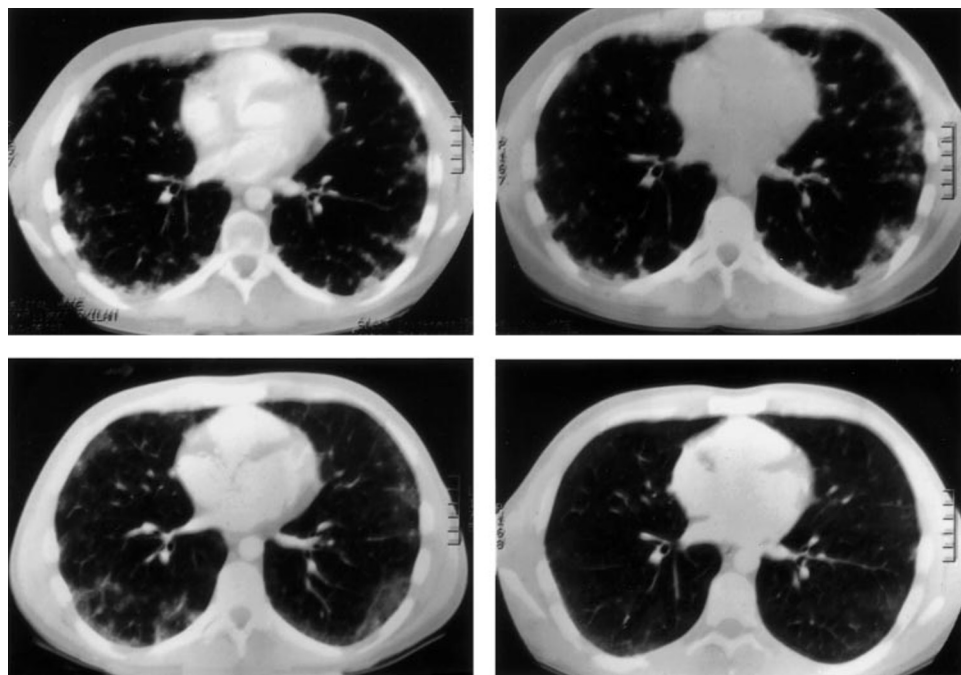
Chest CT scans at the time of presentation (*top left*), 9 months after presentation (*top right*), 18 months after presentation (*bottom left*), and 21 months after presentation (*bottom right*).
